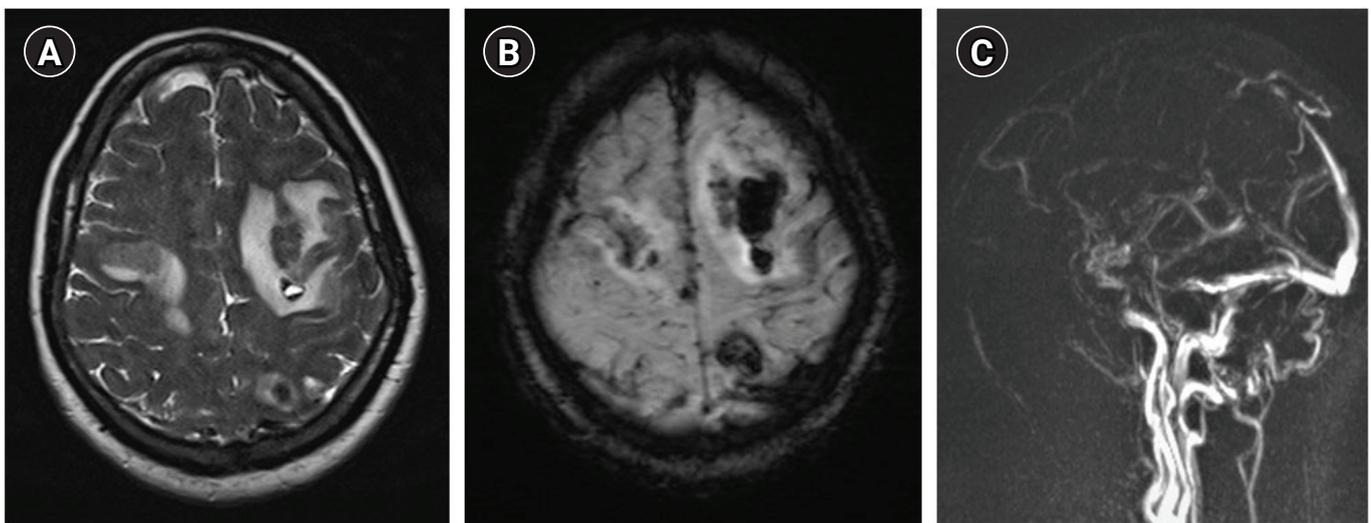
Magnetic resonance imaging of the patient showing bilateral frontal and left parietal hyperintensity on T2-weighted images (A), blooming at the same sites on susceptibility-weighted images (B) suggestive of hemorrhagic infarct and thrombosis of the anterior two-third of the superior sagittal sinus (C) on contrast venography.
